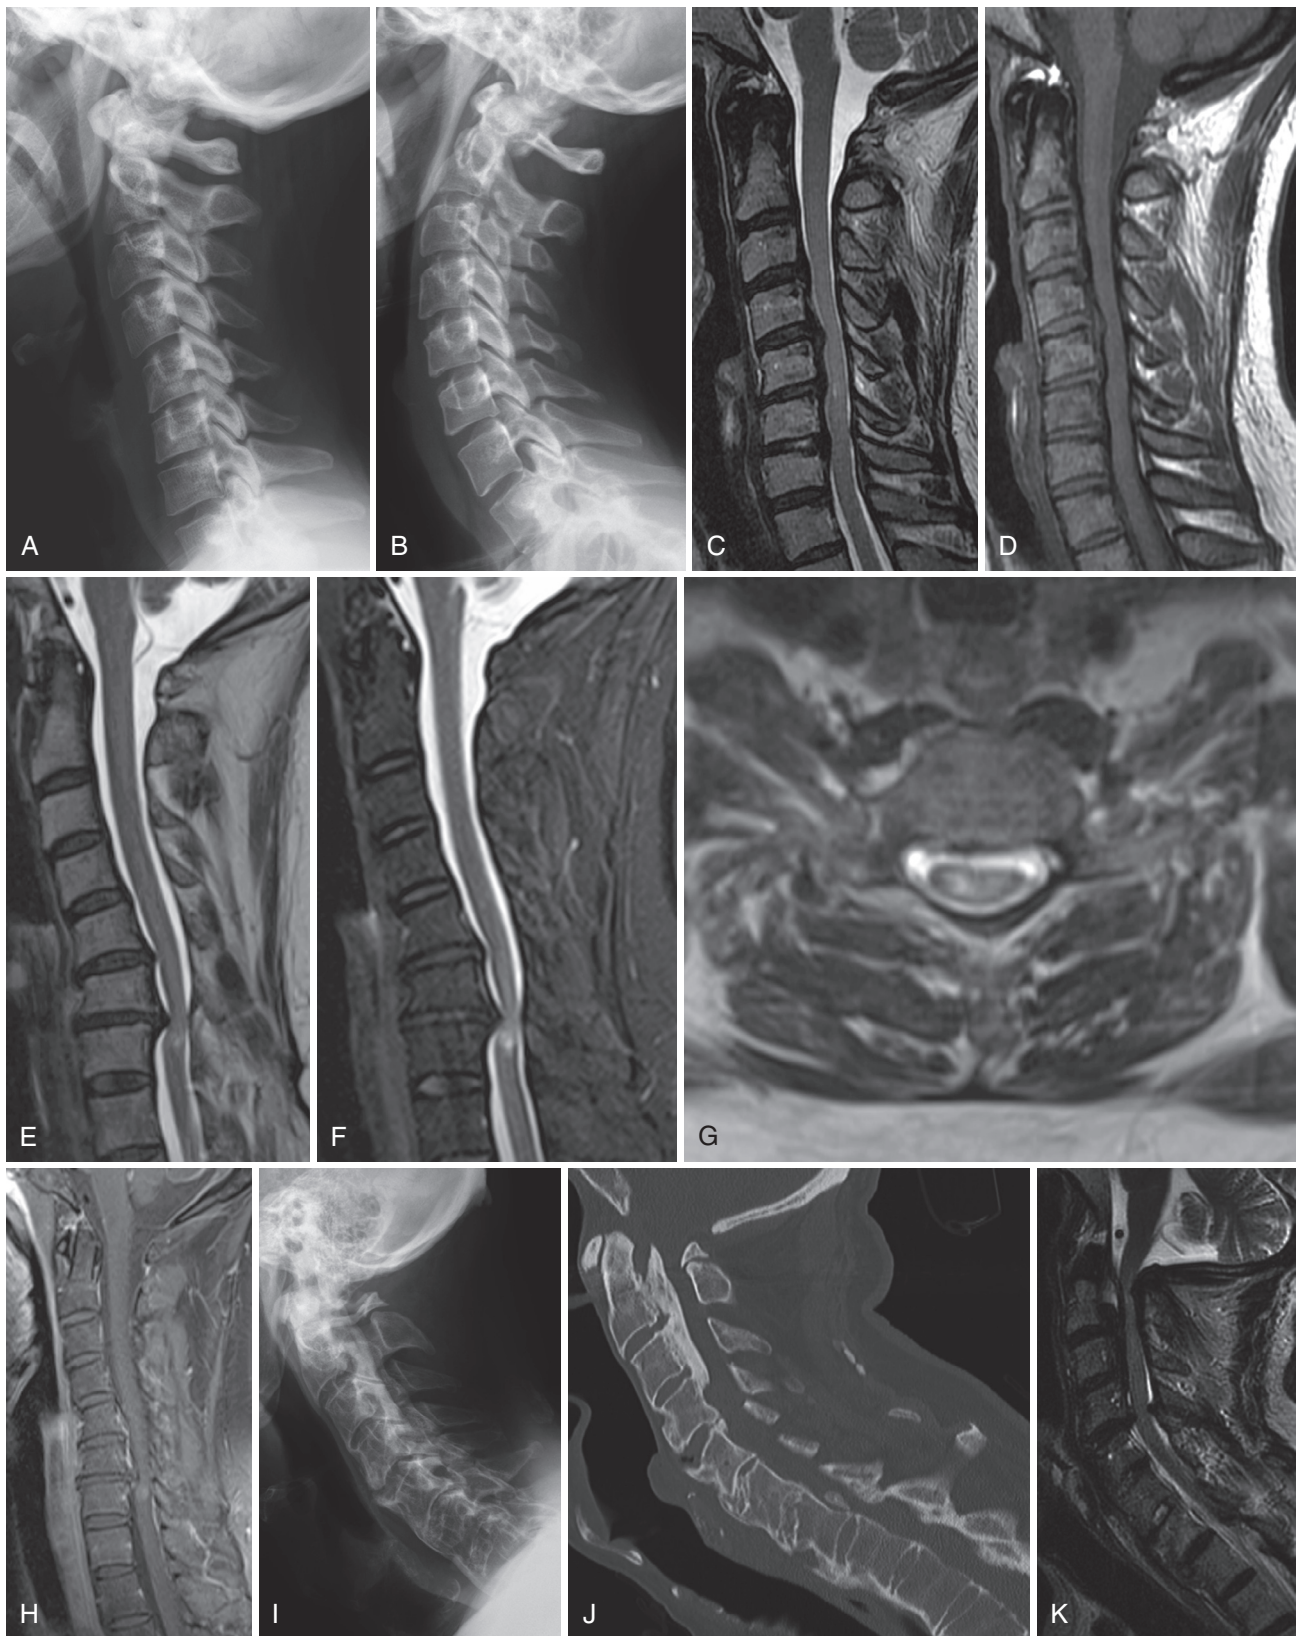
Cervical central canal compromise manifest as cervical spondylotic myelopathy (CSM). A 36-year-old female presents with very subtle bilateral hand incoordination, neck pain, and left arm symptoms. Her lateral radiograph (A) shows no lamina posterior to the articular pillar. Compare to a normal lateral radiograph (B). Sagittal T2 (C) and T1 (D) images show effacement of CSF and cord compression from the C4-C6 interspaces with subtle T2 hyperintensity in the cord at the C5-6 interspace level. Note that no dorsal epidural fat is visible above the C7-T1 level, a typical finding.
